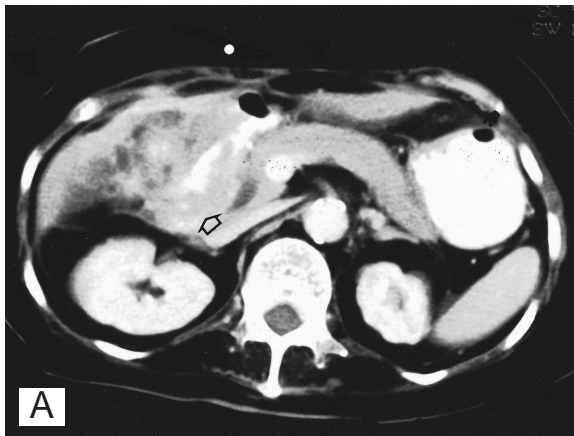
Computed tomographic scan of abdomen. A: A large tumor (arrow) in the duodenum. B: Multiple tumor lesions in the liver.
